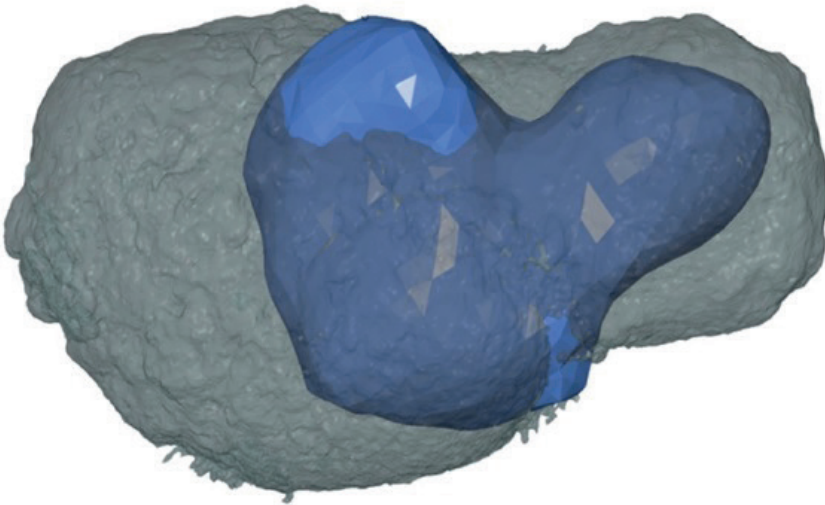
MUCT (blue, volume $258,94\text{mm}^3$) and CBCT (gray, volume $504,42\text{mm}^3$) STL-models projected on top of each other.
